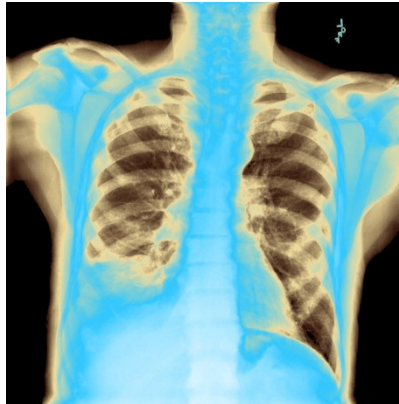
X-ray image after data enhancement
